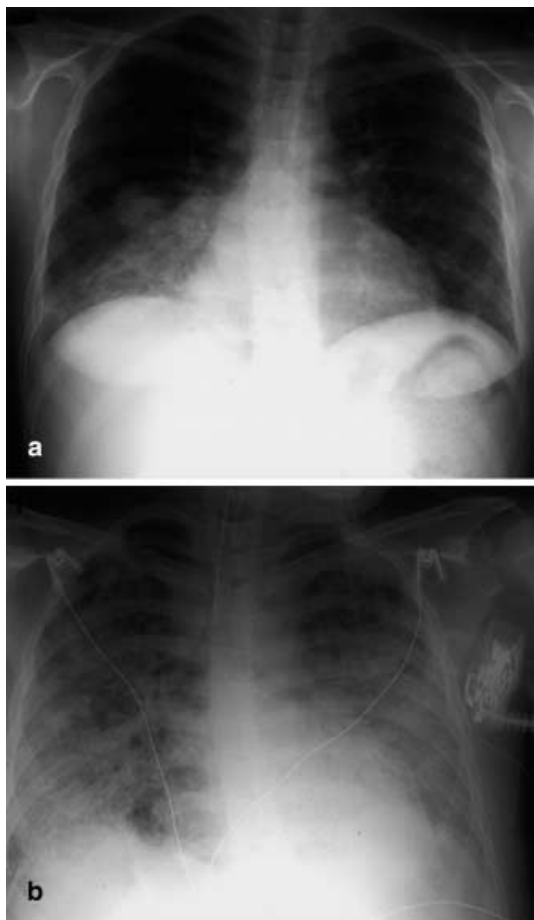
a Posterior-anterior chest radiograph revealing a right lower lobe infiltrate consistent with right basal pneumonia. b Anterior-posterior chest radiograph demonstrating progression of air space disease with severe bilateral consolidation and areas of well-defined rounded lucency within the right lung consistent with pneumatoceles
